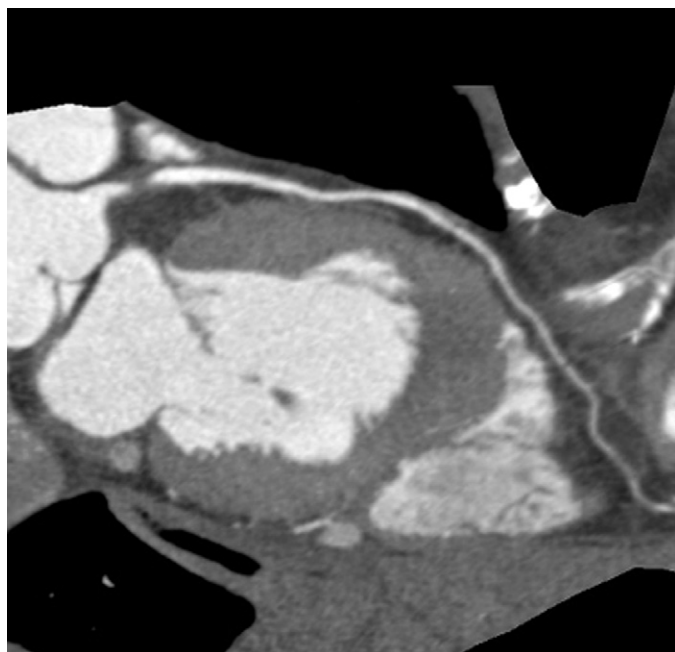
64-Slice CT coronary angiogram showing a significant stenosis in the proximal segment of the left anterior descending coronary artery.
